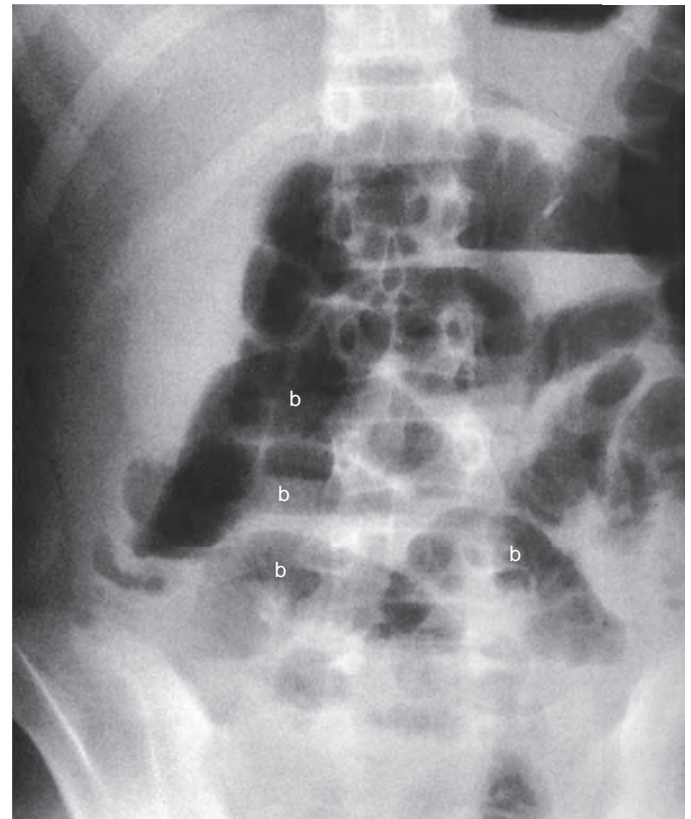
Acute appendicitis causing partial small bowel obstruction. Upright radiograph shows dilation and air-fluid levels in multiple lower abdominal small bowel loops (b). The patient presented with fever and leukocytosis, and gangrenous appendicitis was found at surgery.
